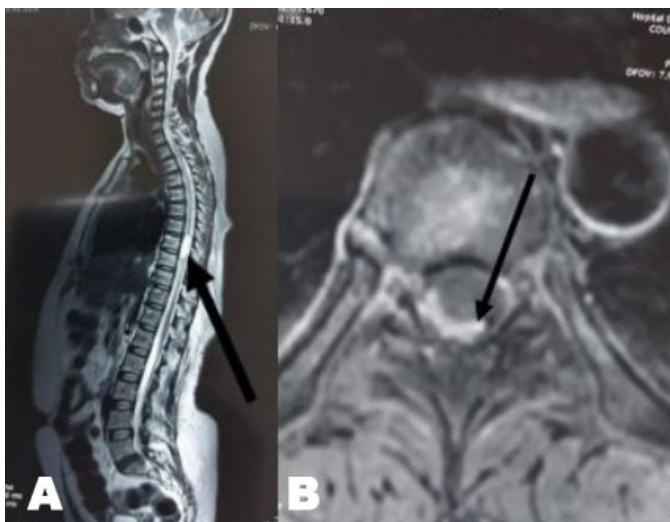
(A) T2 MRI of the spinal cord showing a hyperintense intramedullary lesion with a cystic appearance. (B) The same intradural lesion seen in horizontal section.
